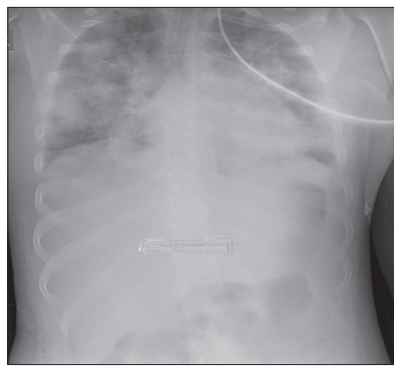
Chest radiograph at admission to the intensive care unit (11 days from the onset of the disease)
